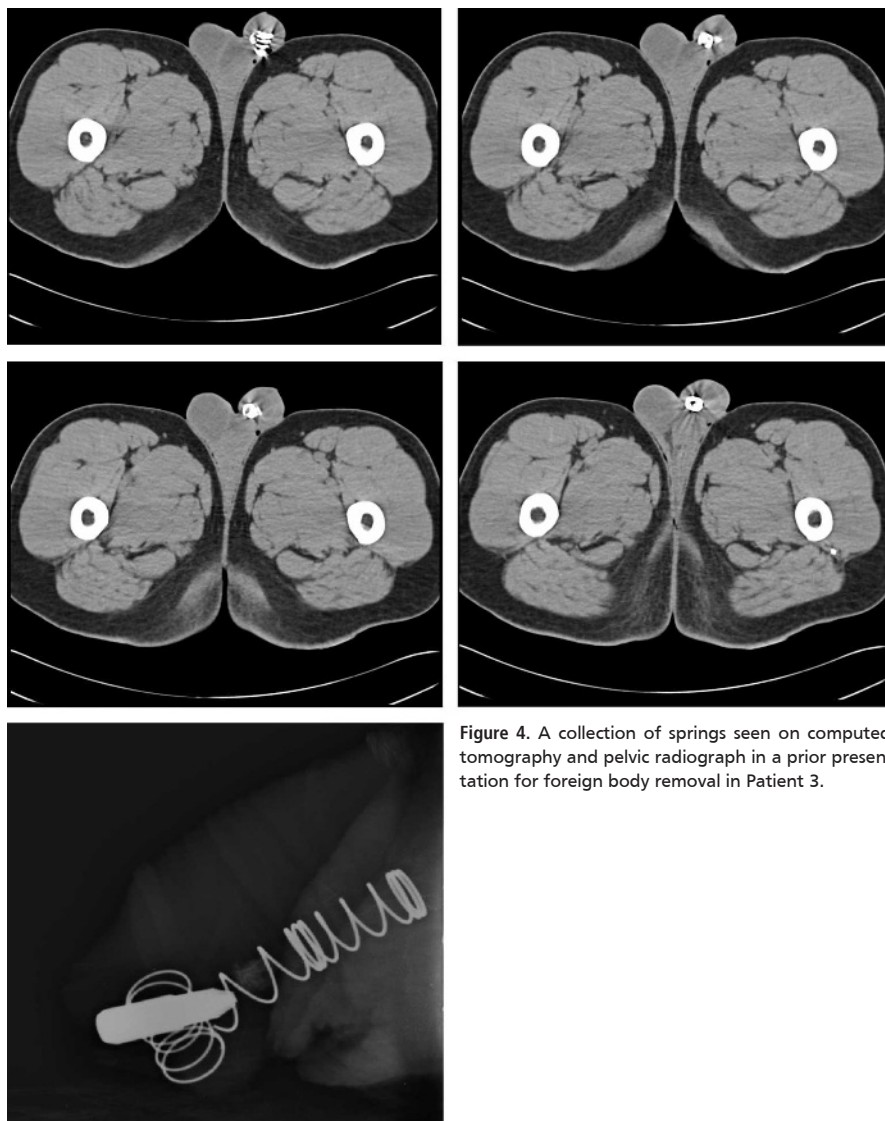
A collection of springs seen on computed tomography and pelvic radiograph in a prior presentation for foreign body removal in Patient 3.
